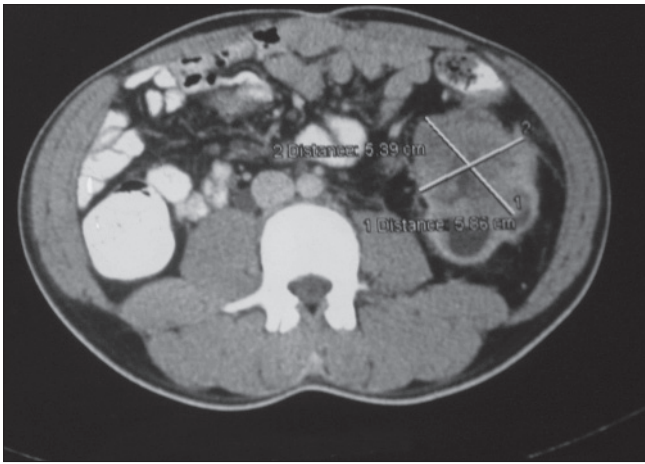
Pretreatment contrast enhanced computed tomography whole abdomen showed pelvicalyceal system is dilated in left kidney due to obstruction caused by an inhomogeneously enhancing mass lesion measuring 5.8 cm × 5.3 cm in the left renal pelvis without any lymphadenopathy, vascular involvement or free fluid in the abdomen. A small calculus is seen in the lower calyx of left kidney
